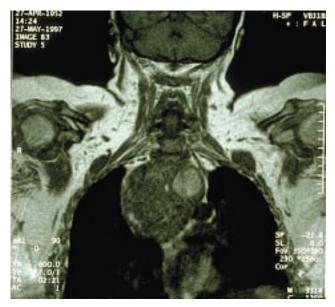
T1-weighted MRI demonstrating a large recurrent intrathoracic goiter. The patient underwent previous subtotal thyroid resection for multinodular goiter. Ten years later dysphagia and stridor due to goiter recurrence occured.
